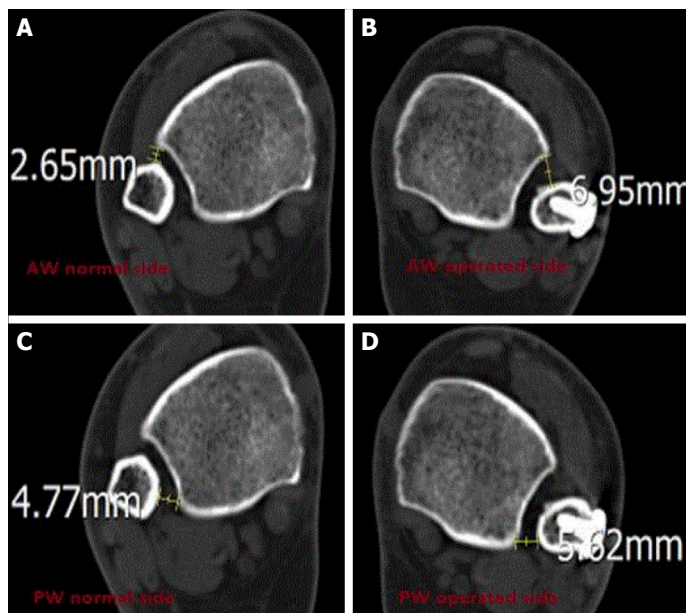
An example of evaluating a case of malreduction on CT by Mukhopadhyay method [7]: normal side (A, B) and operated (C, D). (A) AW normal side, (B) AW operated side, (C) PW normal side, and (D) PW operated side. Mean width of the syndesmosis: $[(\text{AW operated ankle} - \text{AW normal side}) + \text{PW operated ankle} - \text{PW normal side}]/2$, showing more than 2-mm side-to-side difference signifying malreduced syndesmosis $[(6.95 - 2.65) + (5.62 - 4.77)]/2 = 2.4 \text{ mm}$. AW: Anterior widening of tibiofibular borders; PW: Posterior widening of tibiofibular borders.
